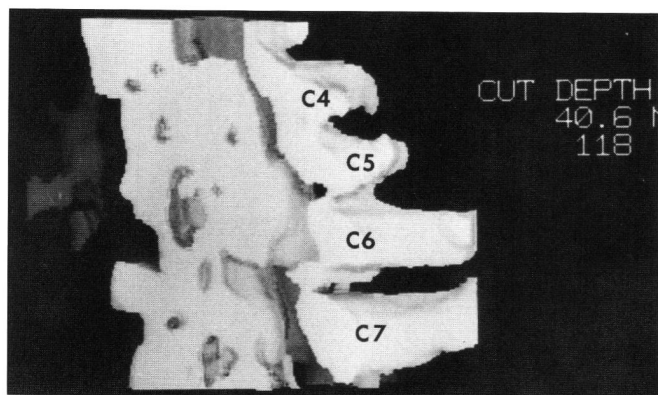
Three dimensional CT. The intraspinal mass starts at C5 and extends down to T1 with irregular undulation in the posterior surface making the canal very narrow. The most significant encroachment is at the C6 level.
